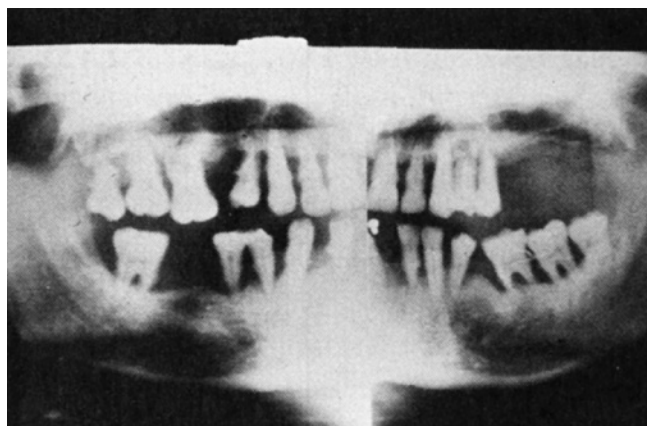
Panoramic radiograph of a young adult with severe, progressive periodontitis. After positive screening for diabetes, the patient was referred to a physician, and the diagnosis of diabetes mellitus was established. The patient required insulin treatment.
